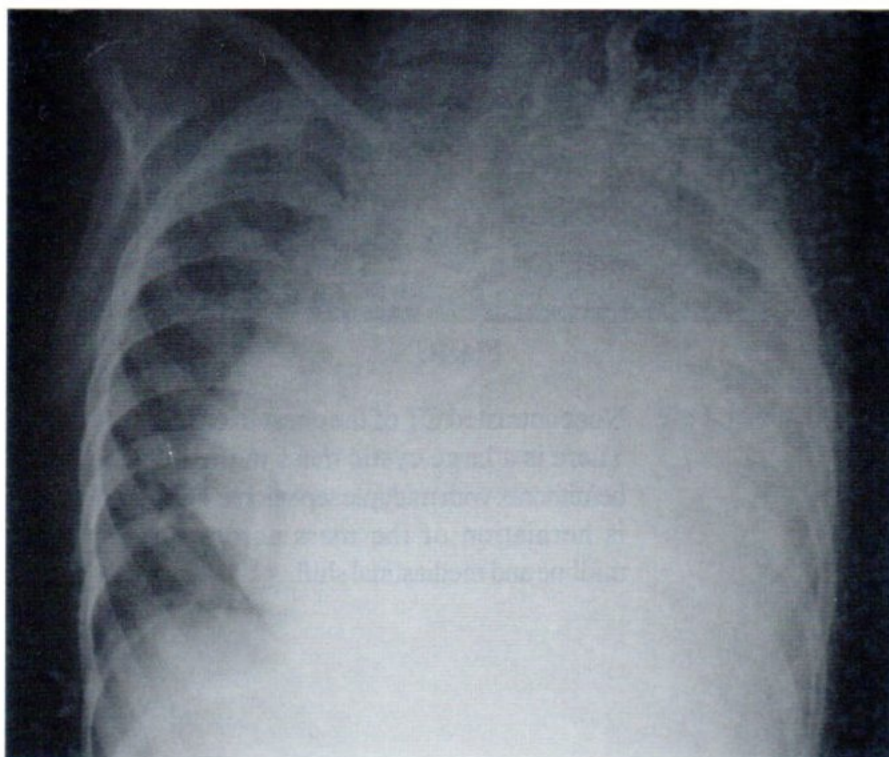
Chest radiograph of a 4-year-old boy (case 2). Opacification of the left hemithorax is seen with shift of the mediastinum to the right.
